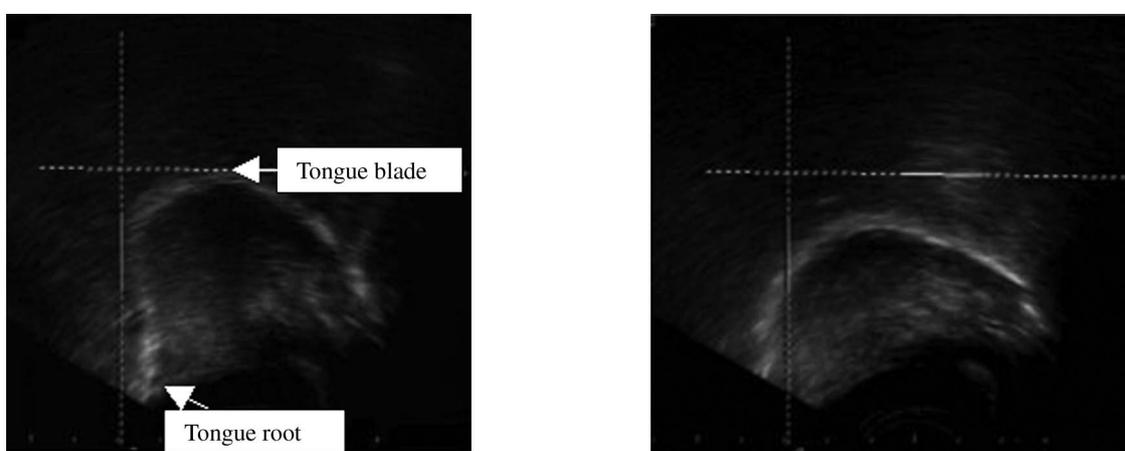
Mid-sagittal ultrasound displays of the English tense vowel /u/ (left), and /ʊ/ (right). The tongue tip is on the right of the image. Note the comparatively high tongue body and advanced tongue root of /u/ compared with /ʊ/.
